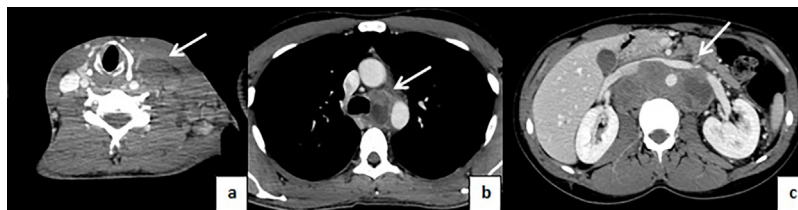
A CT scan of neck (a), thorax (b) and abdomen (c) with contrast revealed the remarkable 6×2.5 cm left lateral cervical lymphadenopathy at the base of the neck compressing and displacing the jugular vein (see arrow); besides, it reported a mediastinal higher lymphadenopathy, in the left paratracheal region (the greater of 2.4 cm) (see arrow) and in almost all abdominal stations, with a voluminous retroperitoneal mass, largely colliquate, with overall diameter of 10.3×5 cm, enveloping and dislocating the abdominal aorta, the renal arteries, the inferior vena cava and the left renal vein (see arrow).
